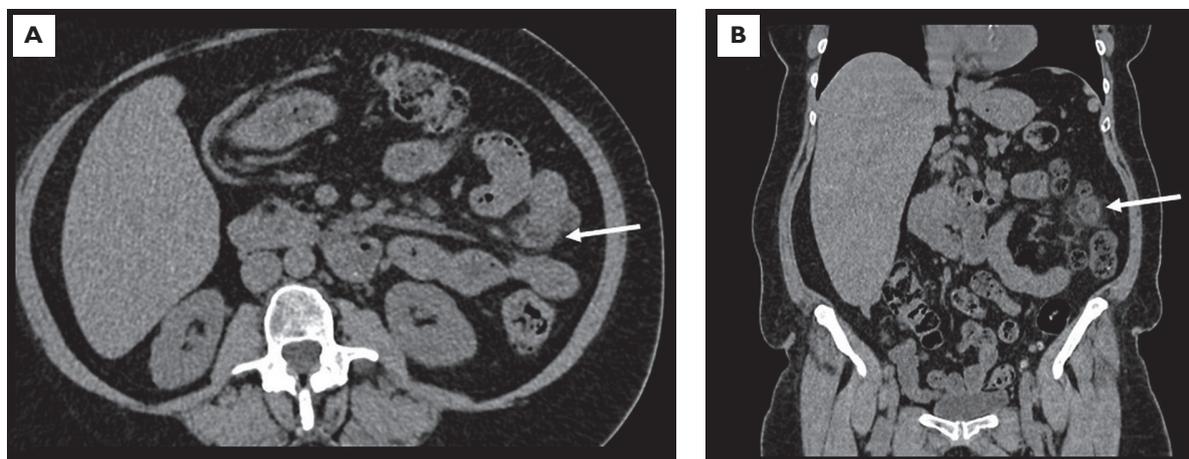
Non-contrast abdominal computed tomography in the axial section (A) and coronal section (B) showing a jejunal diverticulum with adjacent fat stranding, suggesting an inflammatory process.
